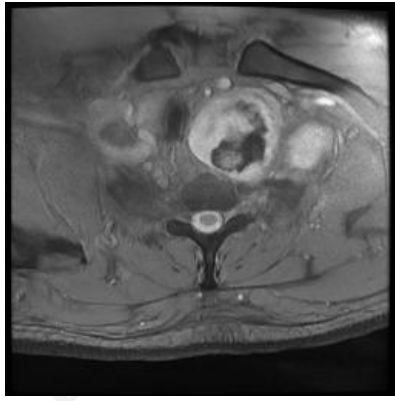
MRI scan demonstrating tumour-related tracheal deviation and compression
